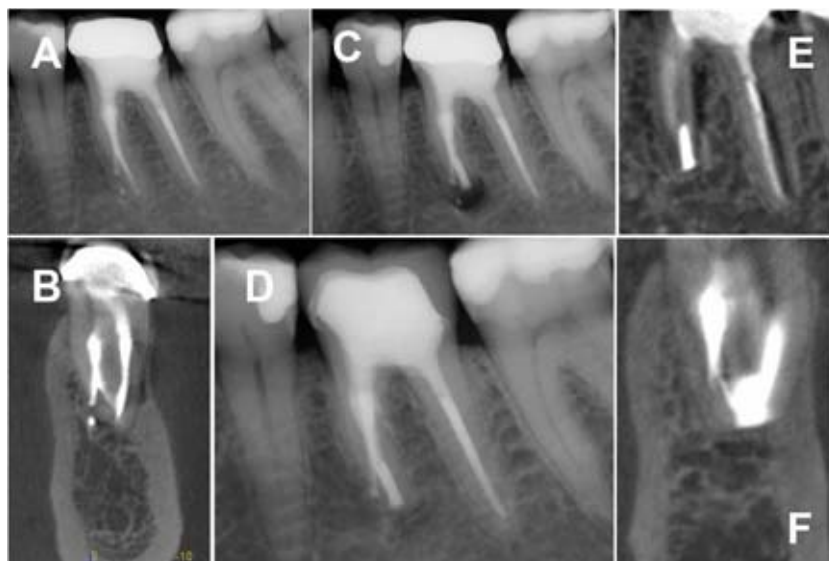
A = persistent complaints occurred in regio 36 after multiple retreatments and a perforation repair. B = coronal view (CBCT) with extruded root canal filling material in the area of perforation repair. C = situation after microsurgical apicoectomy. D = 1-year follow-up (periapical X-ray) with no evidence of pathology. E, F = sagittal and coronal view (CBCT) with complete bony regeneration and perfect bevel angle.
